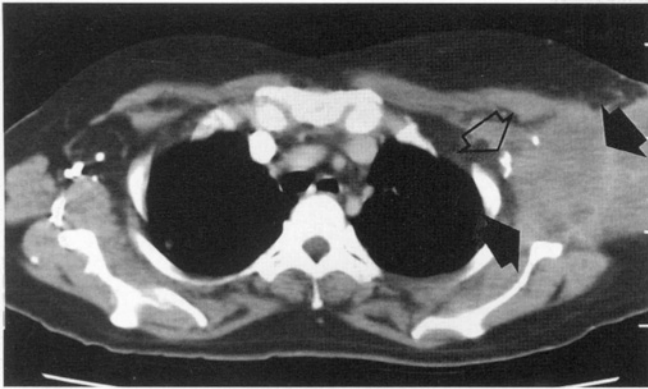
CT scan shows a large metastatic melanoma filling the axillary space. The tumor (solid arrows) involves the subscapularis muscle posteriorly and the pectoralis major muscle anteriorly. The axillary vessels are seen displaced (open arrow). CT and MRI are extremely useful in determining the bony and soft-tissue involvement and extension, respectively, into the axillary space.
